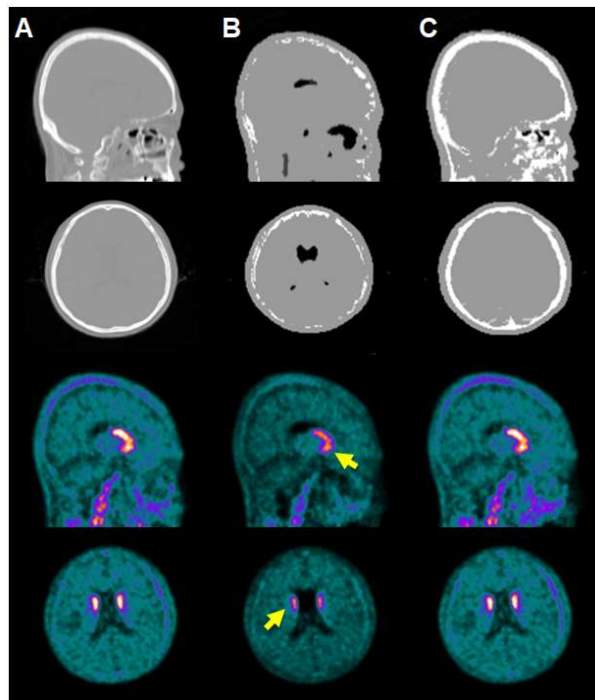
Attenuation maps and $[^{18}\text{F}]\text{FP-CIT}$ PET images corrected using them. (A) CT, (B) $\text{MR-AC}_{\text{mMR}}$: MR-based attenuation map generated using mMR software version VB18P, (C) MR-level : MR-based attenuation map generated using level-set method.
